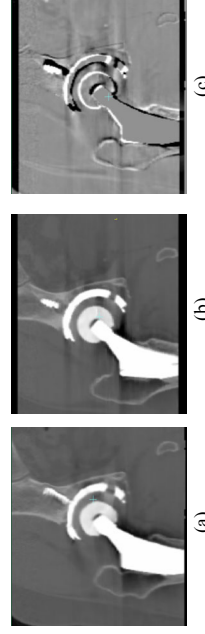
Displacement between registered baseline (a) and 1 year (b) follow-up CT images for the subject with most significant migration measurement (c). This subject received the hip revision.
